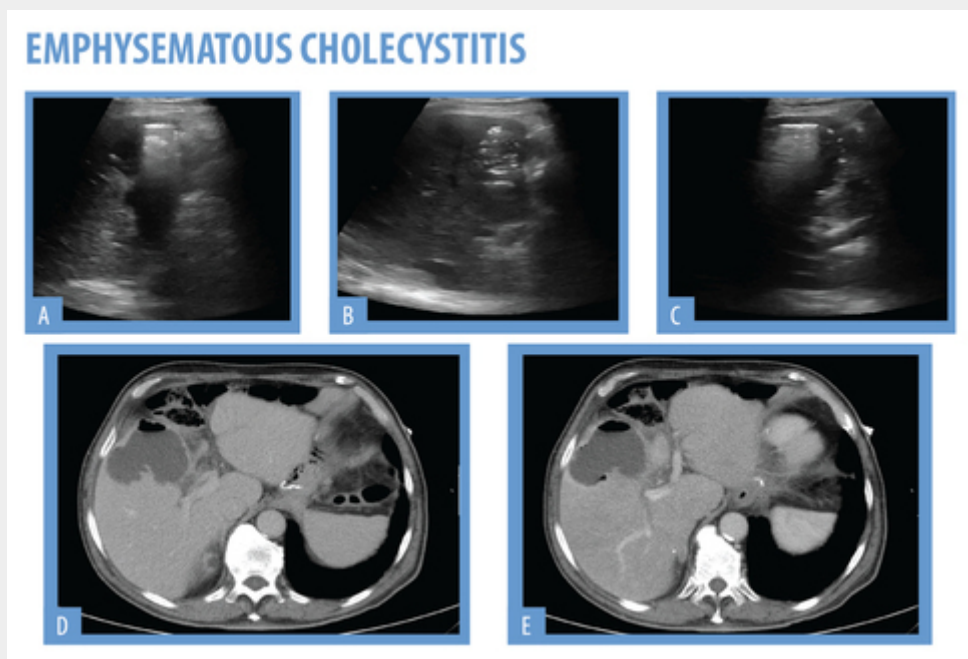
74 year-old diabetic patient. Presented with intense RUQ pain, fever and hypotension. On US (A,B,C) the gallbladder is filled with heterogeneous content, containing multiple foci that cast a "dirty shadow". There appears to be air in the gallbladder wall. The patient underwent CT (D, E) which corroborates the US findings.
